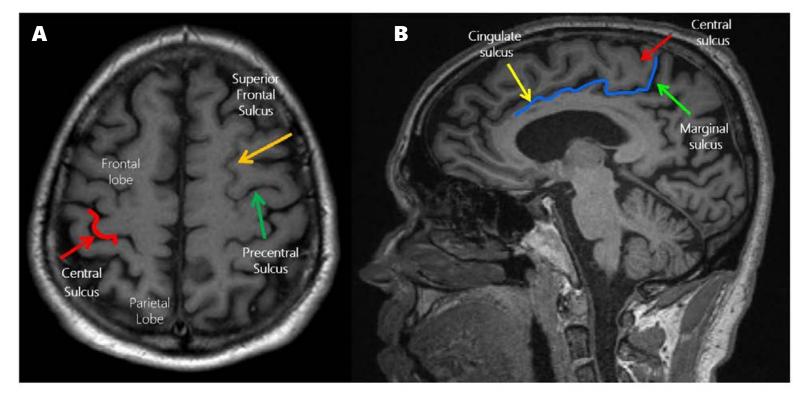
Axial (A) and sagittal (B) T1-weighted MRI image showing the normal anatomy of the sulci mentioned in the text.
